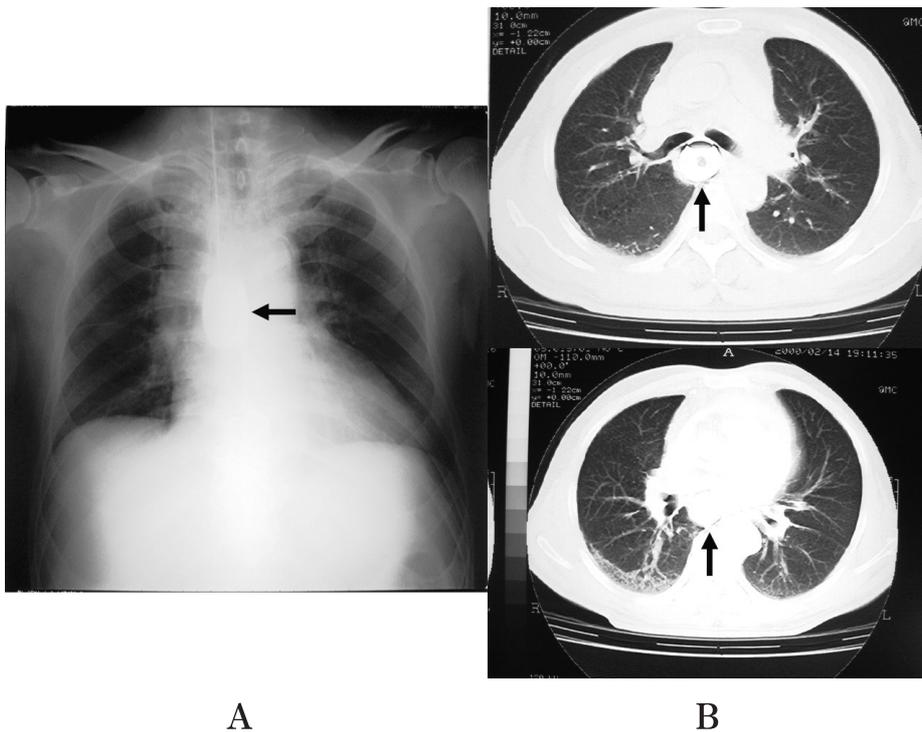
Chest X-ray and thoracic CT radiographs of case No. 2 with the intubation of the WB
